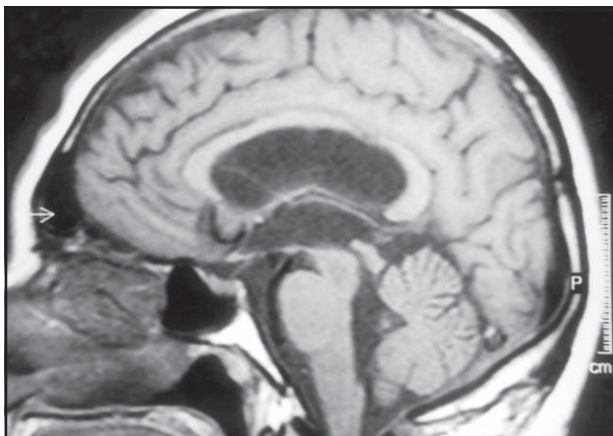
Follow up T1 MRI with gadolinium showing no signs of hydrocephalus and a normal fourth ventricle.
